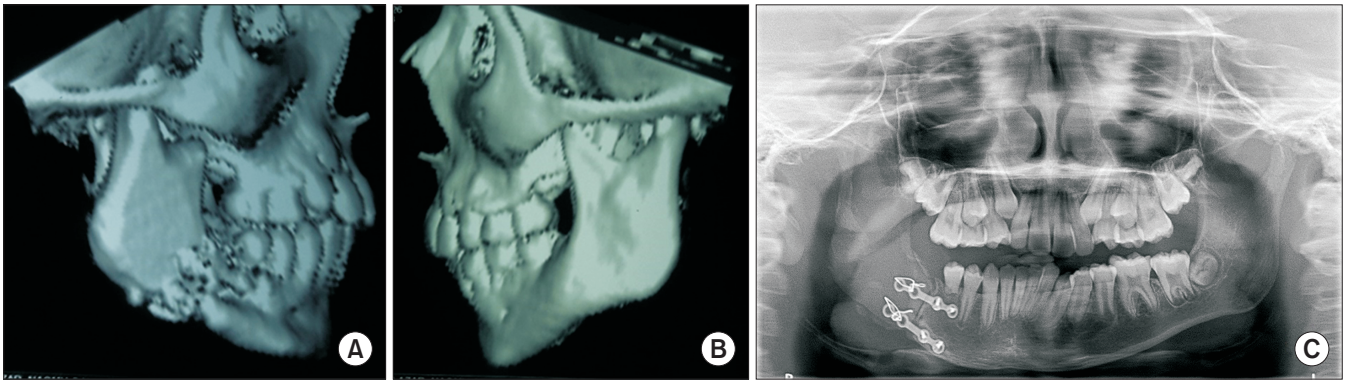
Patient monitoring images: computed axial tomography (A and B: 3D reconstruction images), two years postoperative, and orthopantomography (C), three years postoperative. Note on the radiograph, the right lower second premolar tooth, which erupted despite the absence of root formation.
